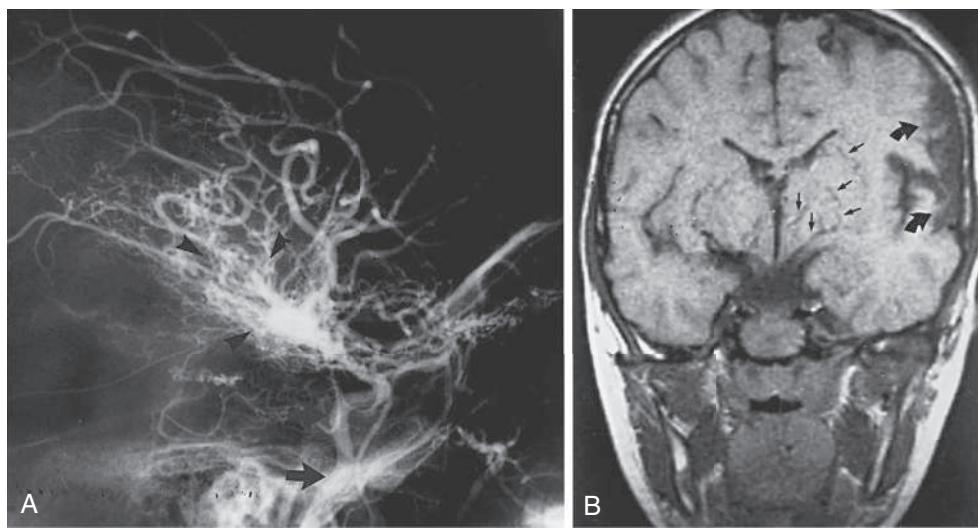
Sudden onset of right hemiparesis in a 6-yr-old male. A, Cerebral angiogram shows the left internal carotid artery (arrow) leading to a highly arborized, telangiectatic network of vessels (arrowheads) characteristic for moyamoya disease. The typical middle cerebral artery vascular tree is absent. B, Cranial coronal MRI scan shows region of low signal in the middle cerebral artery territory and denotes infarction (curved arrows). Flow voids in the basal ganglia (straight arrows) are radiographic manifestations of the basilar collateral circulation typical of this vascular anomaly. (From Farias-Moeller R. Stroke. In Kliegman RM, Toth H, Bordini BJ, Basel D, eds. Nelson Pediatric Symptom-Based Diagnosis, 2nd ed. Philadelphia: Elsevier; 2023, Fig. 37.17, p. 653.)
